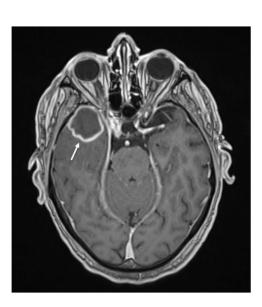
Magnetic resonance imaging (MRI) of the brain with gadolinium administration showing a smooth ring-enhancing lesion in the right temporal pole with adjacent sulcal effacement and significant vasogenic edema.
